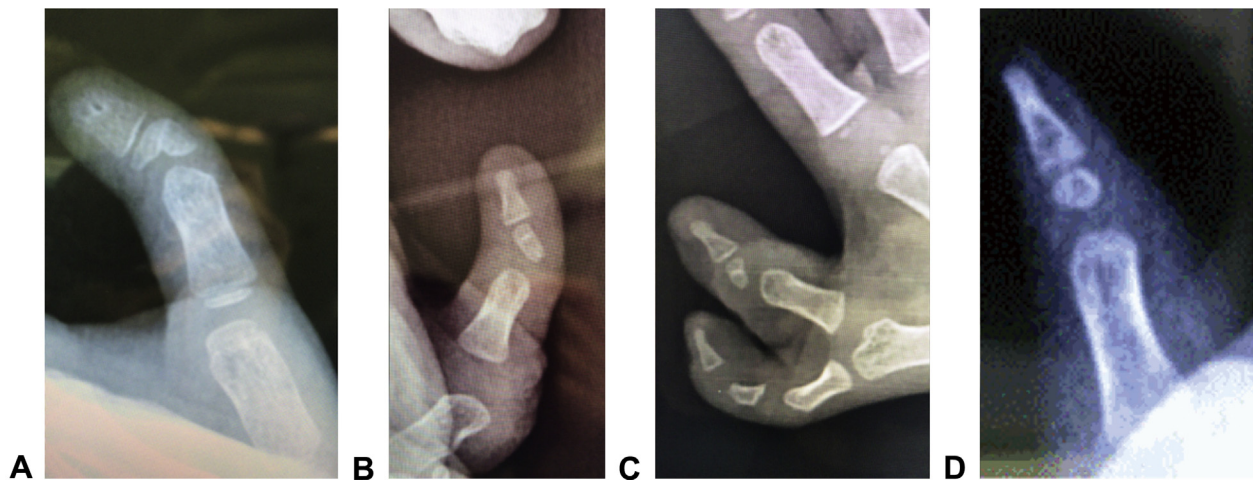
Radiographs showing different shapes of abnormal hypertrophic epiphyses, resulting in ulnar deviation of the thumb: A triangular, B oval, C trapezoidal, and D round.
